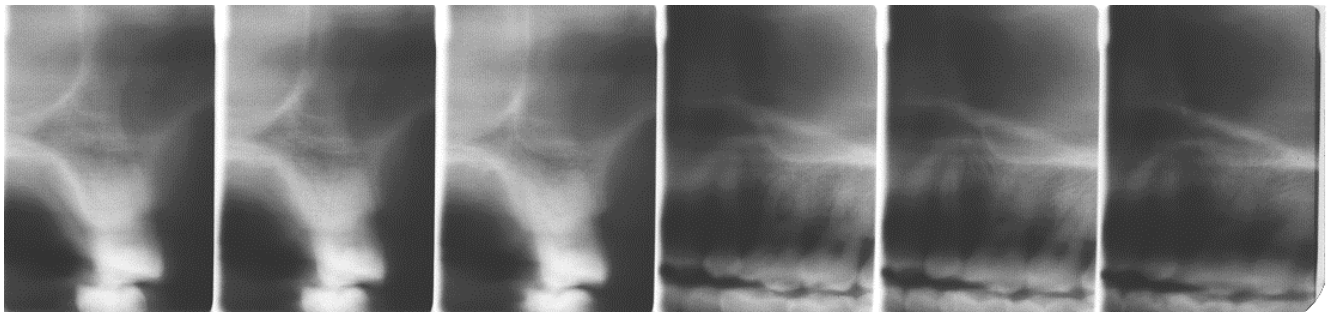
Tomographic images of Orthopantomograph OP100 (Instrumentarium, Tuusula, Finland). Orthogonal views are generated from distal to mesial (left half of figure) and from buccal to palatal (right half of figure). Courtesy of Instrumentarium Oy and J. Mudrak.
